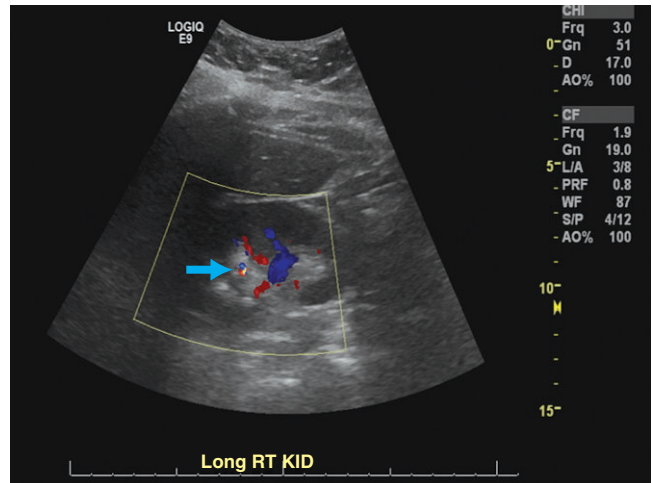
Color Doppler imaging of the same echogenic focus demonstrates the "twinkle artifact" posteriorly (arrow), most consistent with a renal stone.
